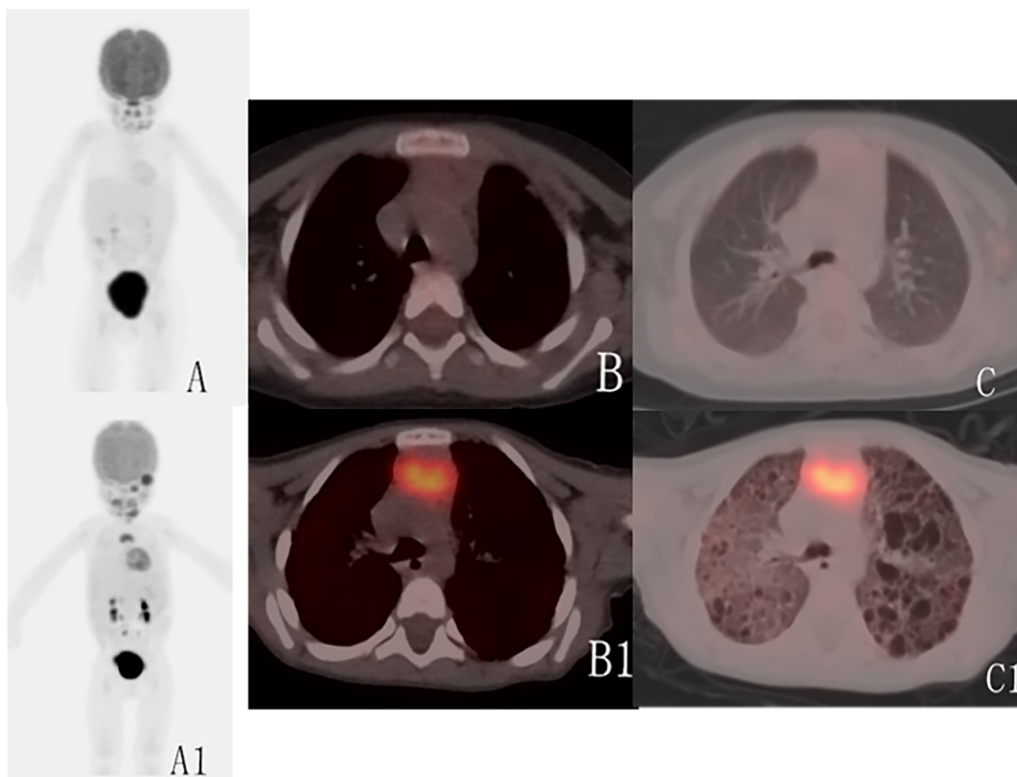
Comparison of PET/CT imaging of a 1-year-old girl with multi-system LCH. Imaging after chemotherapy (A-C) show metabolic activity of LCH lesions and cystic spaces in lung significantly decrease than imaging before chemotherapy (A1-C1).
